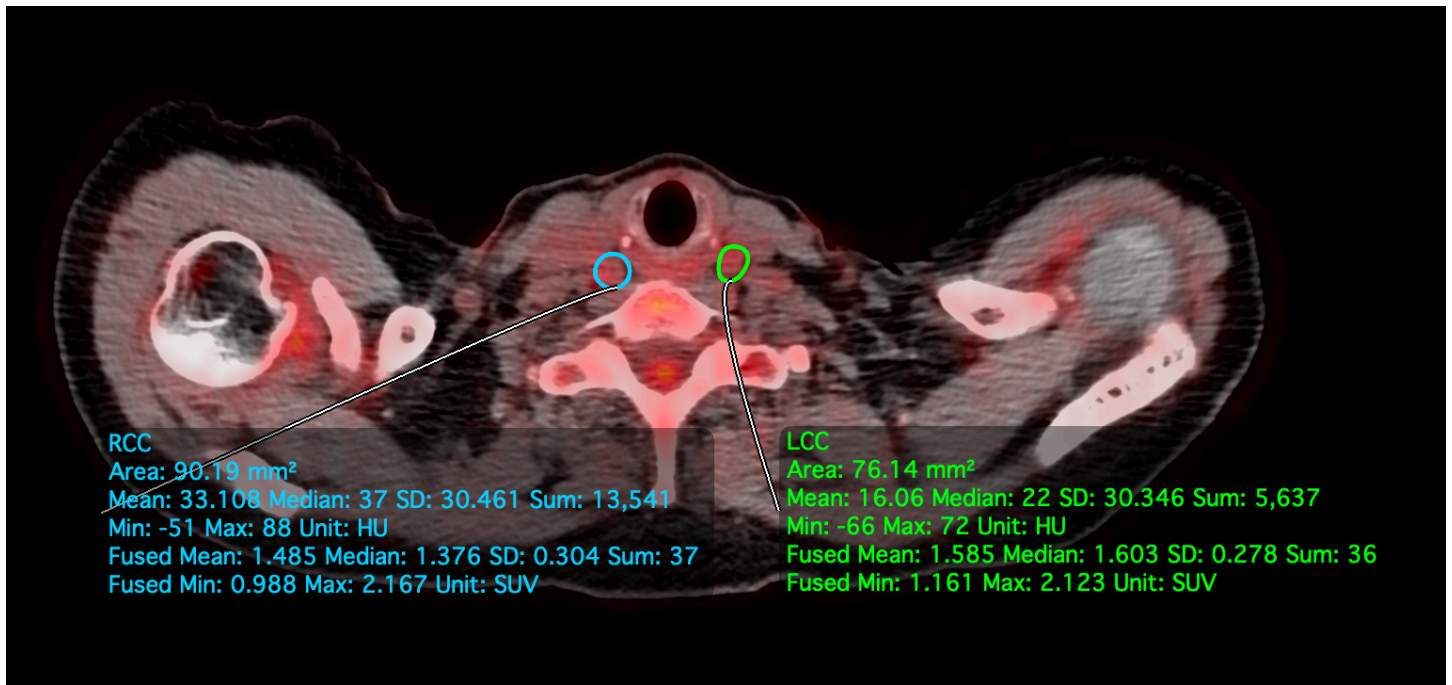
Quantitative assessment conducted by defining regions of interest (ROI) around the left (LCC) and right (RCC) common carotid arteries. LCC was the primary measure of carotid atherosclerosis in this study. For the drawn LCC ROI, SUV_{mean} = 1.585, SUV_{min} = 1.161 and SUV_{max} = 2.123.
